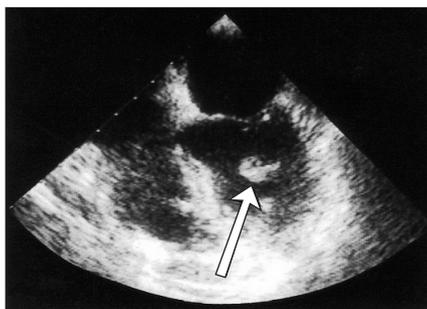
Echocardiogram demonstrates a mass (arrow) in the left ventricle.
